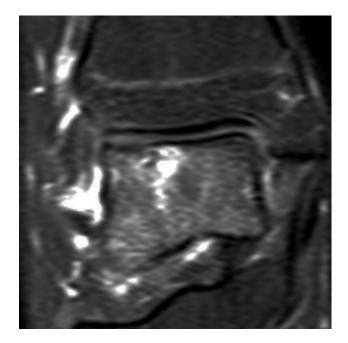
Coronal magnetic resonance image displaying an osteochondral defect preoperatively.
